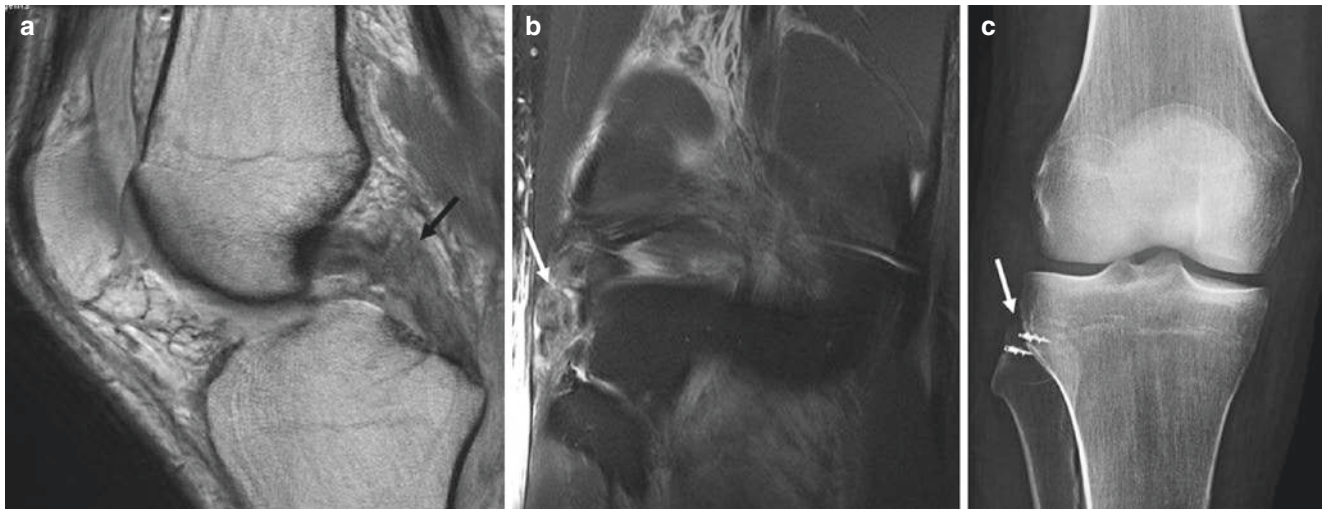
(a) Sagittal proton density MR image demonstrates a PCL tear (arrow). (b) On the coronal fat suppressed T2 weighted image there is an associated posterolateral corner injury (arrow). (c) The
